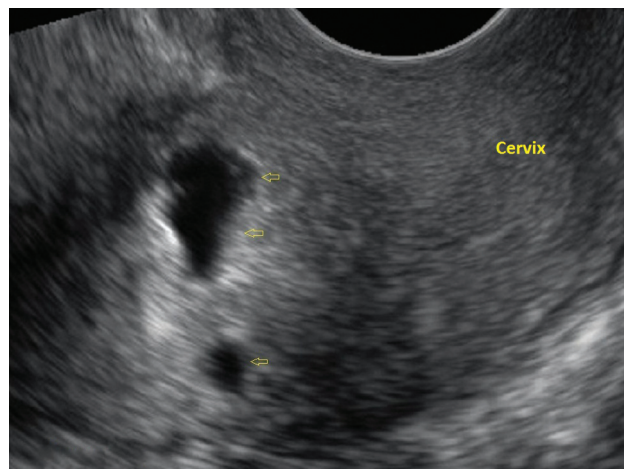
TVUS after 10 days of a vaginal delivery; ruptured CS scar (arrows). CS, cesarean section; TVUS, transvaginal ultrasound.
